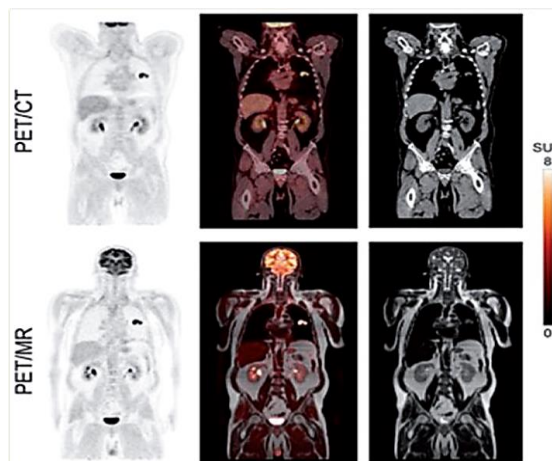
PET/MR and PET/CT Pictures of the Same Patient [25]. About one Hour After Injecting 15 mCi of 18F-FDG, PET/CT Imaging was Performed, and one Hour and Ten Minutes Later, PET/MR Imaging was Performed.
